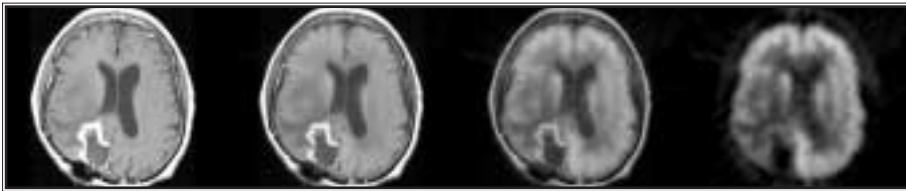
62-year-old woman status postresection of a right occipitoparietal glioblastoma multiforme followed by chemotherapy and radiation therapy. Contrast-enhanced T1 MR image reveals increasing enhancement, and FDG-PET scan demonstrates enhancement to be hypermetabolic, which was documented to be recurrent tumor.
